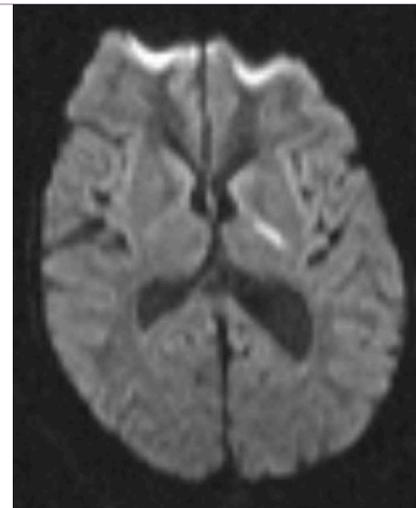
MRI brain showing acute infarction involving the posterior limb of the left internal capsule.
